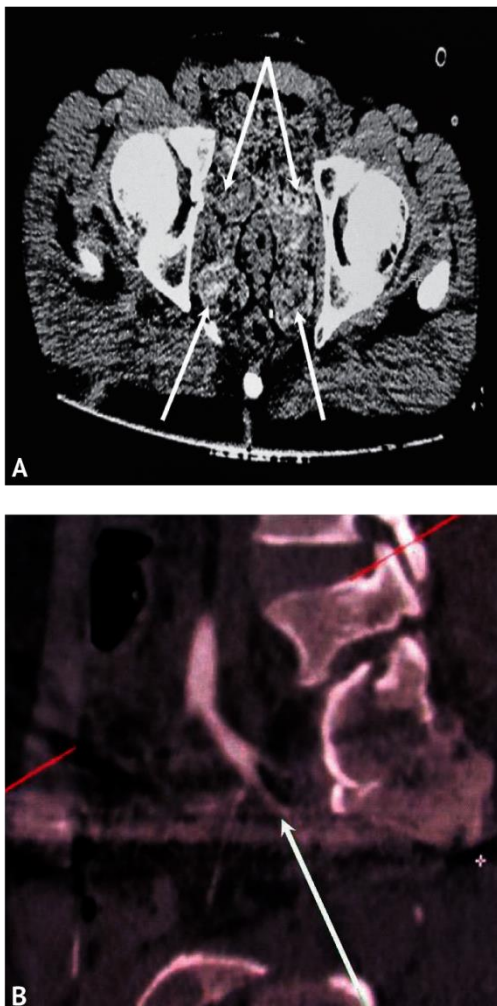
CT scan of the pelvis with intravenous contrast: A — axial plane at the level of the acetabulum (arrows indicate tampons); B — failure of contrasting at the level of the anterior trunk of the right internal iliac artery (indicated by the arrow)
